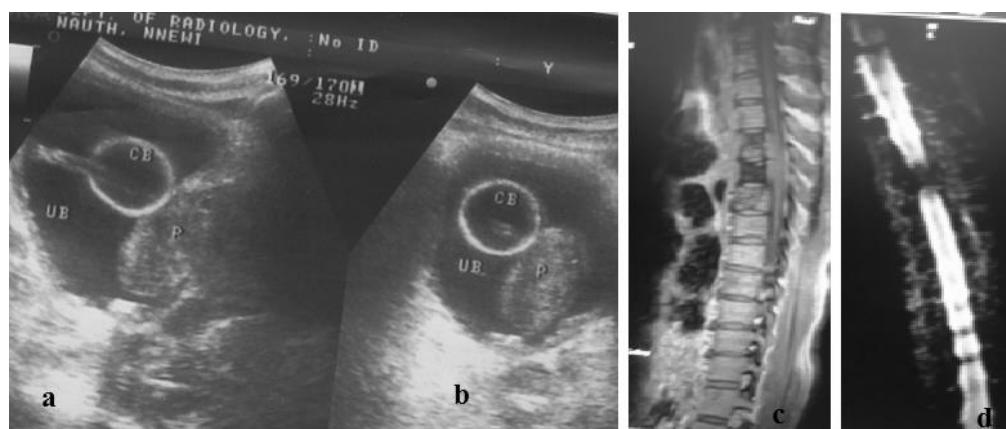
Transverse, a. and sagittal, b. sectional views of pelvic sonography showing enlarged prostate (P), protruding into the urinary bladder (UB) of an elderly man who presented with paraplegia. The round structure is catheter bulb (CB). Spinal MRI; c. shows metastases in the vertebral bodies. MRI myelogram, d. Shows spinal cord compression by the masses at various positions.
